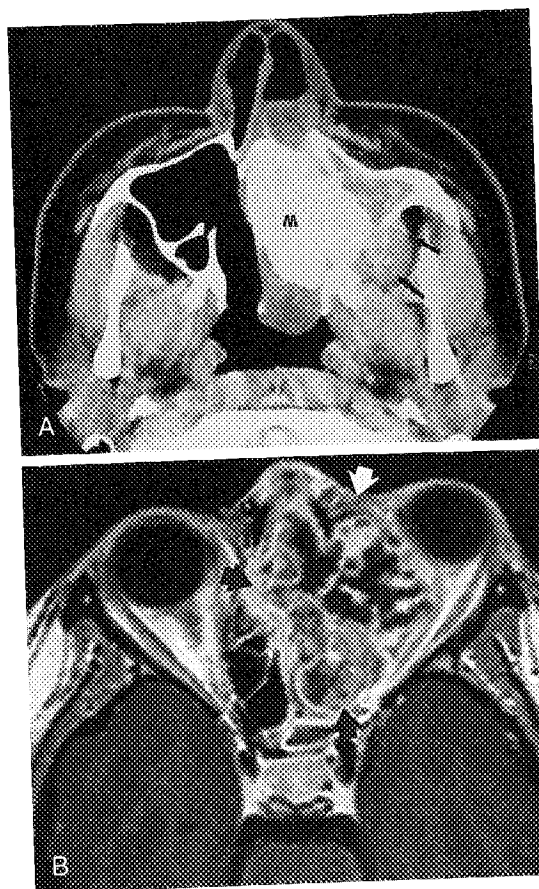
A, CT scan shows destructive mass (M) with marked intratumoral bone formation. Note tumor bone formation in the soft tissue component in the infratemporal fossa (arrows). B, Enhanced T1-weighted MR image shows heterogeneous contrast enhancement of osteosarcoma (arrows).
